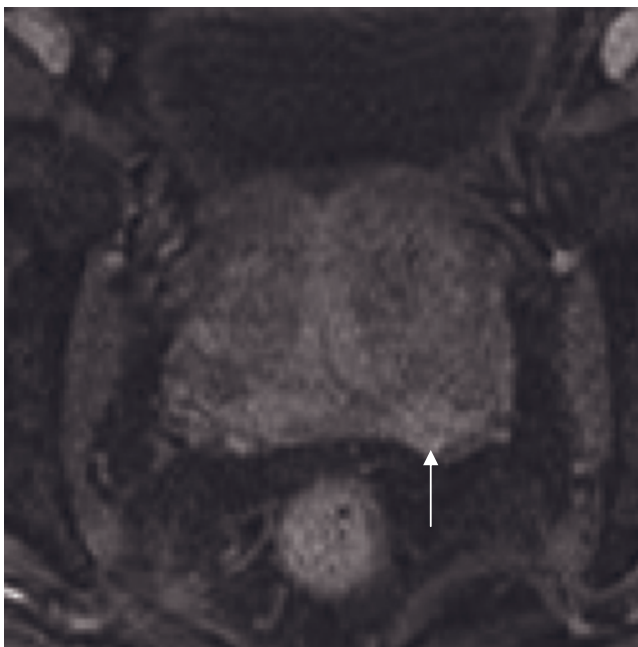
Prostate adenocarcinoma Stage T2. Transverse T2-weighted ETSE endorectal image (a). A focus of low signal intensity is seen within the peripheral zone in this patient with Stage T2 adenocarcinoma of the prostate (arrow, a). Endorectal transverse T2-weighted ETSE image (b) in a second patient with prostate carcinoma. A hypointense tumor is seen within the peripheral zone of the prostate at the level of the apex (arrow, b). Endorectal coronal T2-weighted ETSE image (c) in a third patient with prostate carcinoma. A low-signal-intensity focus within the apex of the prostate represents primary adenocarcinoma (black arrow, c). Note the incidental midline utricular cyst, which is high in signal intensity on the T2-weighted image (white arrow, c).
